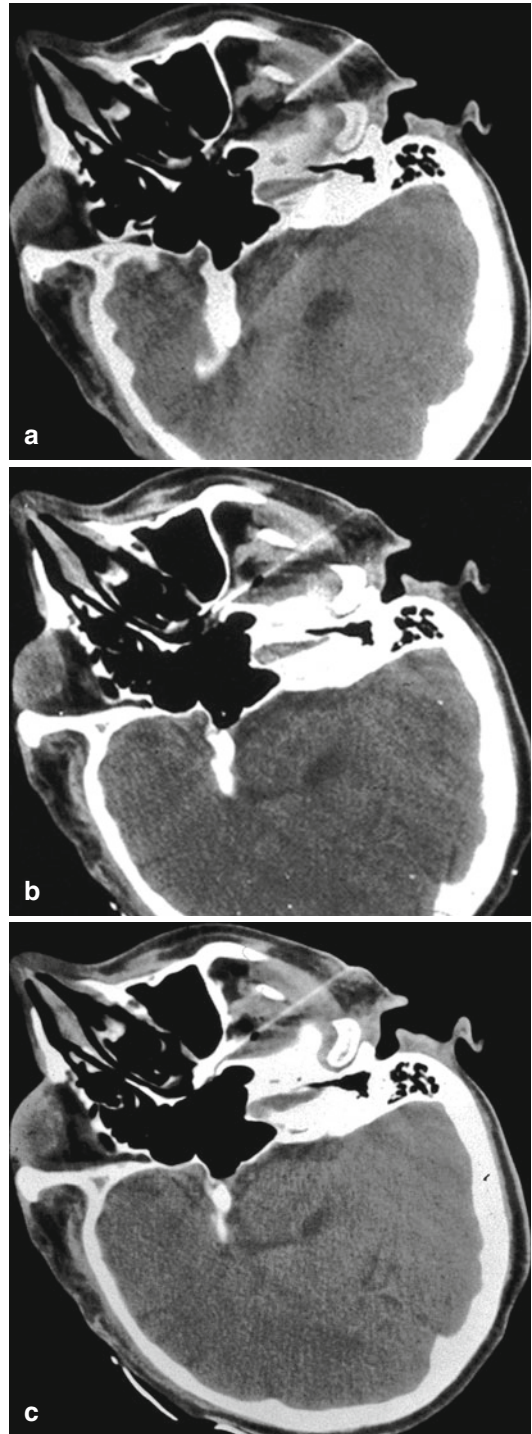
Pterygopalatine ganglion neurolysis: The needle is placed under step-by-step CT guidance (a, b), and contrast media with a local anesthetic is injected to assure correct needle tip position on the target. Finally, 1 ml of absolute alcohol is slowly instilled (c)
